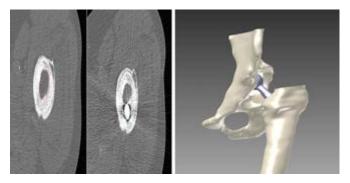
Evolution from CT to 3D reconstruction
